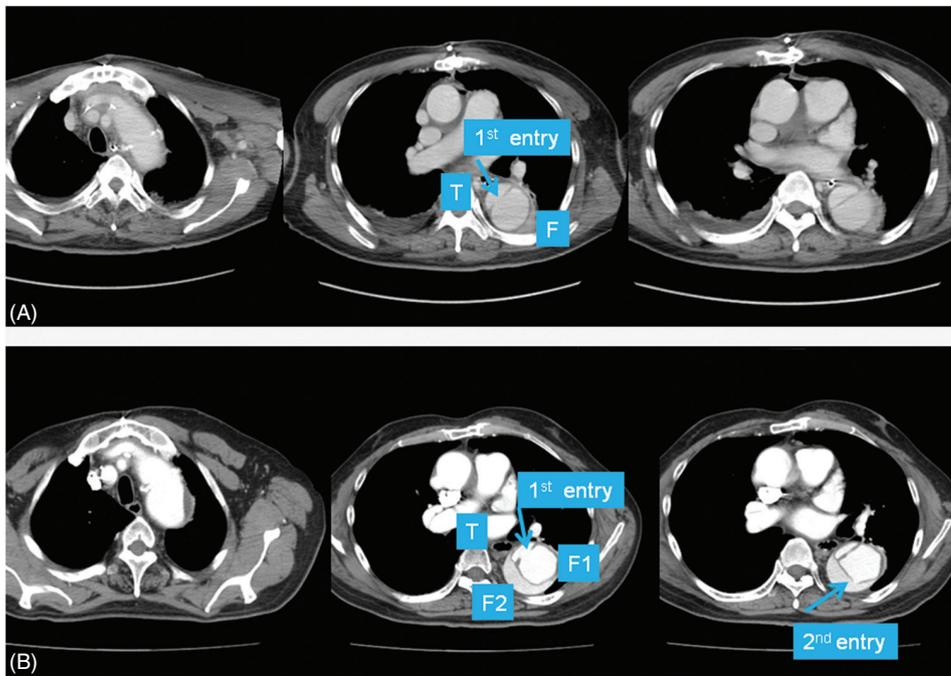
(A) Computed tomography scan demonstrates post-total arch replacement in 2008 for aortic dissection in chronic period. The entry site of the first aortic dissection could not be removed at this surgery. (B) Computed tomography scan demonstrates the three-channeled acute aortic dissection on admission in 2012. The second entry site of three-channel aortic dissection was shown. T: true lumen; F1: previous false lumen; F2: new false lumen
